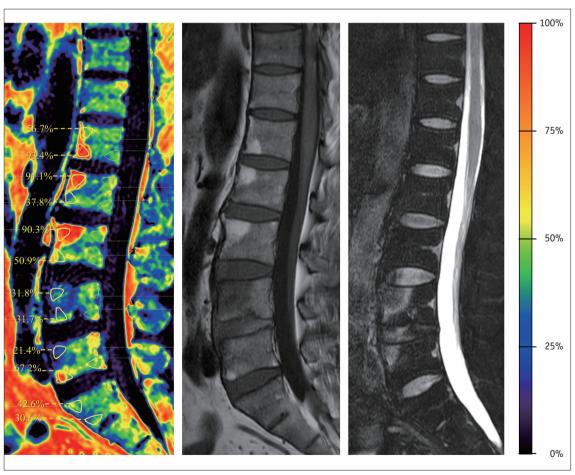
Color fat fraction (%) map and non-fat suppressed T1-weighted and fat-suppressed T2-weighted sagittal magnetic resonance imaging of the L-spine. The regions of post-inflammatory fat deposition, normal marrow, and active inflammation are colored red, green or yellow, and blue, respectively. Post-inflammatory fat depositions are visible in the anterior corners of L1, L2, L3 bodies and bone marrow edema are visible in the anterosuperior corners of the L4 and L5 bodies. L = lumbar
